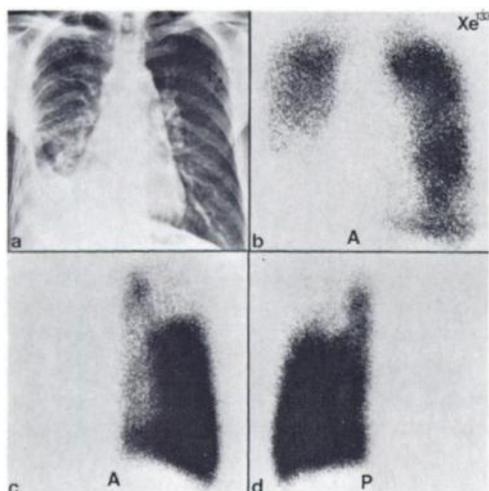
Case 2. (a) Chest radiograph showing pleural thickening and loss of right-lung volume. (b) Anterior Xe-133 scan showing air distribution as in chest radiograph. There was no delay in wash-out images. (c, d) Tc-MAA scans show unmatched perfusion defects.
